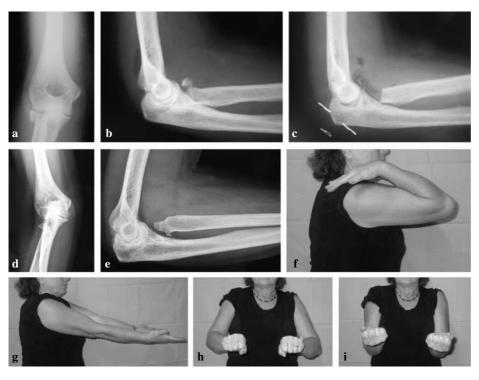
A 50-year-old woman with a Mason type III fracture of the right radial head. a, b Preoperative radiographs. c Postoperative radiographs at the 11-year follow-up show degenerative changes of grade 1 and the formation of a neocapitellium. f Mean flexion of the elbow was 145°. g There was no loss of elbow extension. h Pronation of the forearm measured 90°. i Supination measured 90°. The overall outcome was excellent
